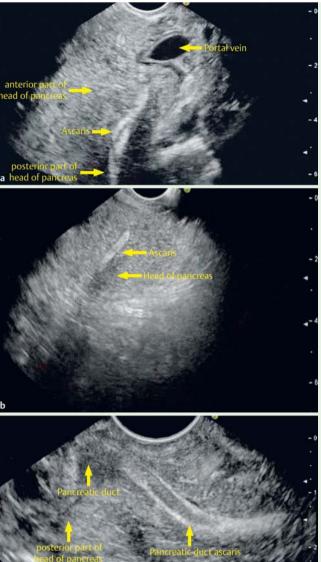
Endoscopic ultrasonography (EUS) was done for investigation of idiopathic recurrent acute pancreatitis in a 30-year-old man. a A linear echogenic shadow was seen in the pancreatic duct within the head of the pancreas. b EUS from the duodenal bulb demonstrated the ascaris worm in the head of the pancreas. c EUS from the descending duodenum showed a linear shadow with two hyperechoic linear echogenic strips on either side of the longitudinal anechoic lumen of the ascaris worm.
